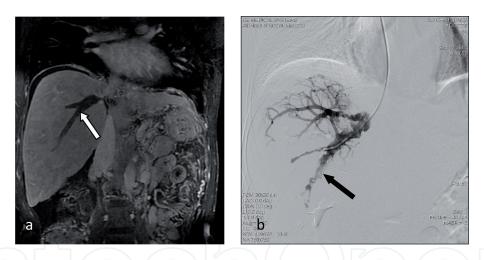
Hepatic vein occlusion combined with thrombosis. (a) MRI showing the right hepatic vein occlusion with thrombosis (white arrow). (b) DSA showing hepatic venous occlusion with thrombosis (black arrow).
